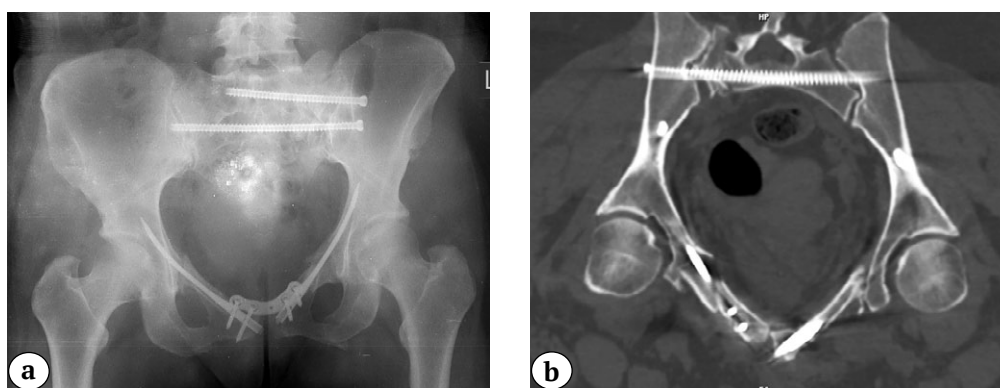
Postoperative X-ray: anterior fixation with the nail-plate system and sacral fixation with cannulated screws in S1 and S2 (a); 2D CT reconstruction of the pelvis postoperatively confirming restoration of the pelvic ring anatomy with fixation of the sacrum, pubic bones, and symphysis (b)
